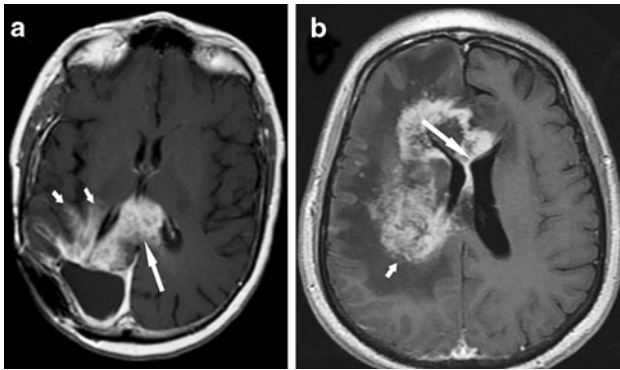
a T1-enhanced MRI in TCN shows a right parietal “spreading wavefront” margin of enhancement (*short arrows*). There is solid internal enhancement. Enhancement is also present in the splenium of the corpus callosum (*long arrow*). b The “spreading wavefront” peripheral enhancement pattern (*short arrow*) is present in another patient with TCN. The MRI also demonstrates enhancement in the corpus callosum and periventricular/subependymal regions (*long arrow*)
